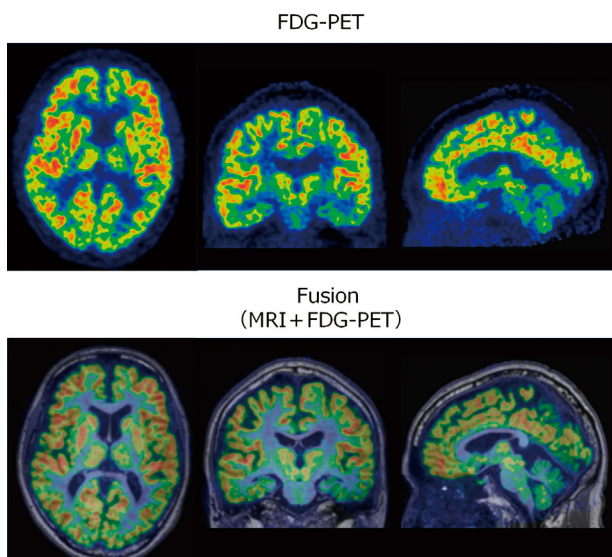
Head FDG-PET (Slice) Images (Top) Obtained with Prototype System and MRI/FDG-PET Fusion (Slice) Images (Bottom)
